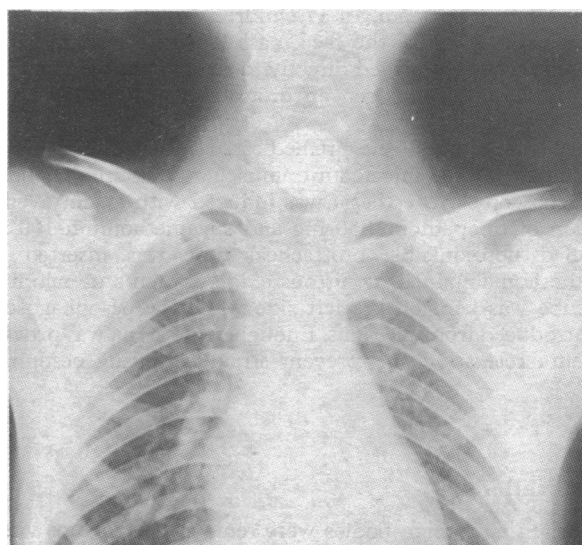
Anteroposterior chest x-ray picture of child showing coin impacted at upper oesophagus opposite 6th cervical vertebra.
